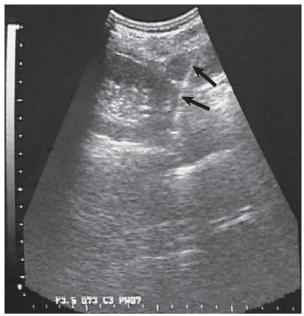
Renal biopsy imaging. Ultrasound scan shows the needle entering the lower pole of the left kidney. *Arrows* indicate the needle track, which appears as a fuzzy white line.
